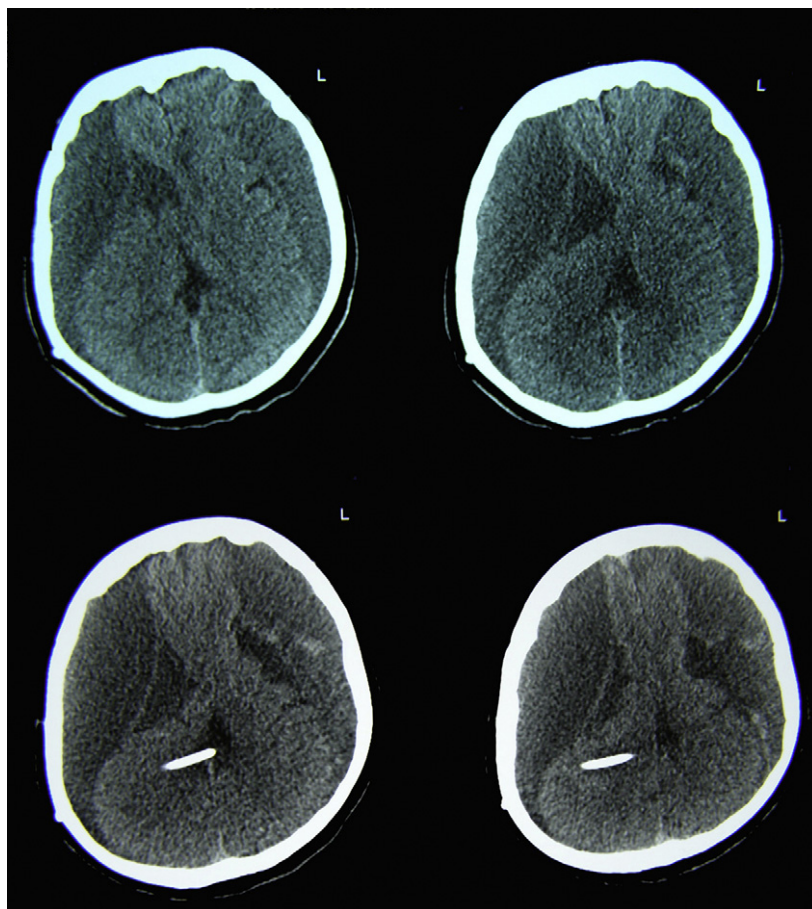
Head CT, 72 h after trauma, revealed a bilateral subdural hematoma, causing a serious mass effect.
